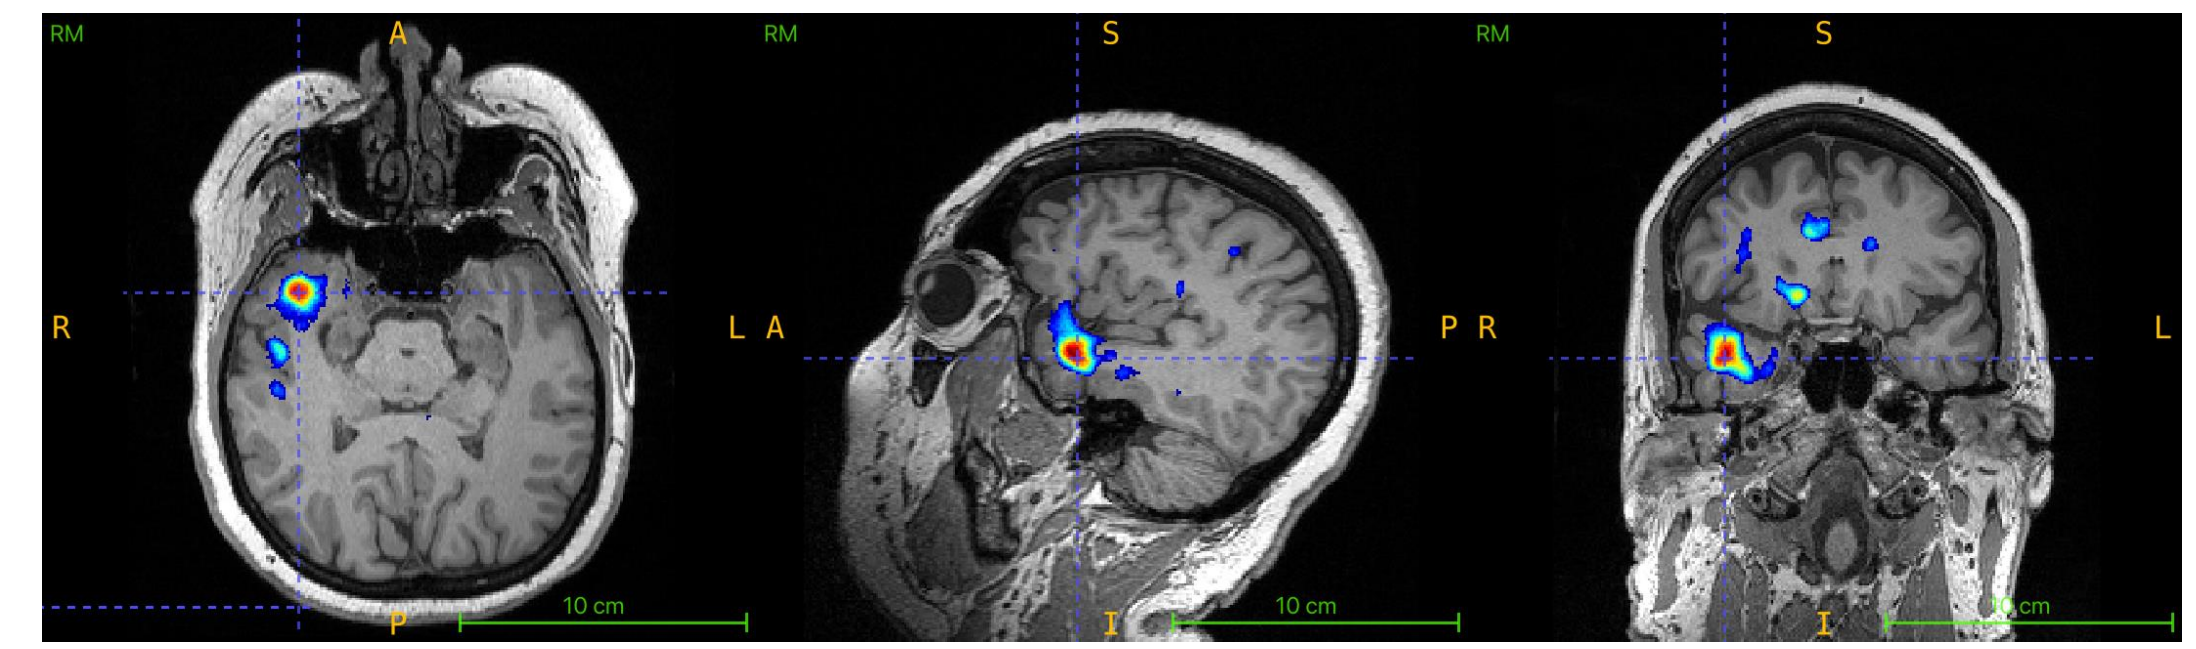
Epileptogenic focus localized on the MRI using the Z-score normalization method.
